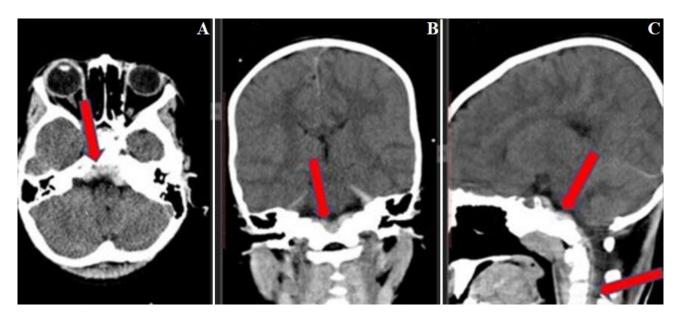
A) axial CT; B) coronal CT; C) sagittal CT scan demonstrating retroclival subdural hematoma extending from the dorsum sella to the C4 cervical subdural space
